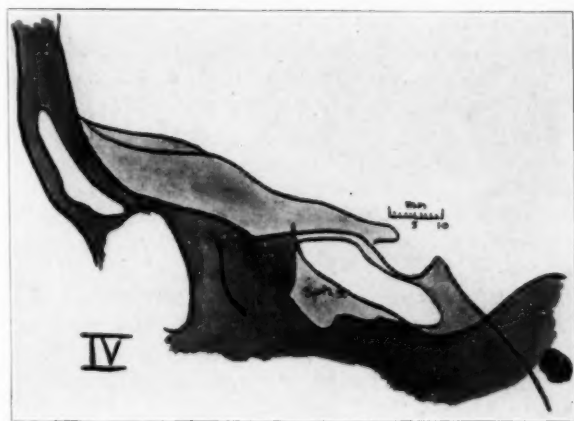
(case 4).—A sketch of the roentgenogram (fig. 10), drawn to scale.
